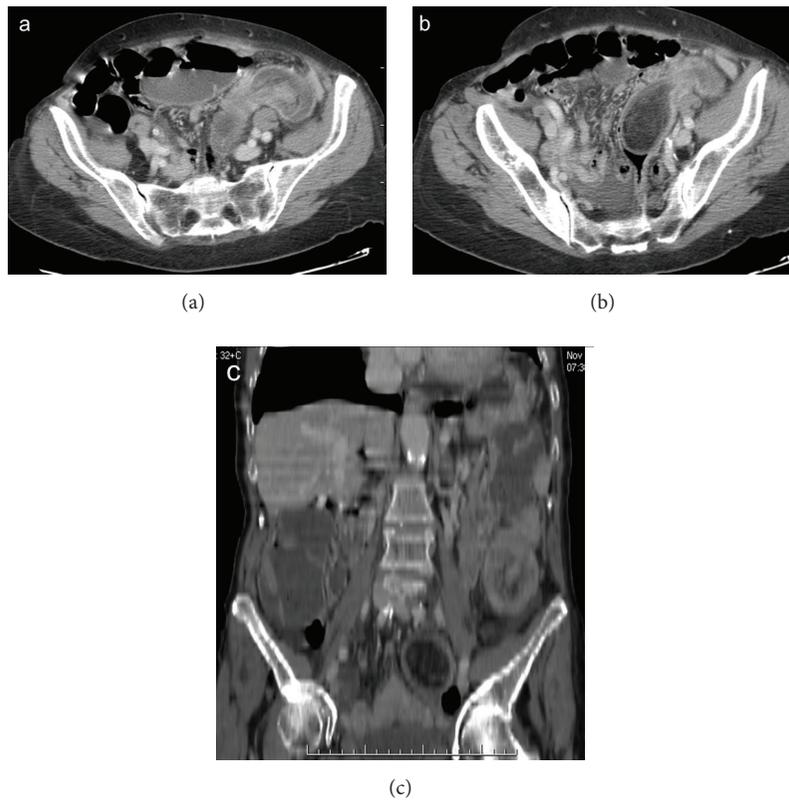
Colocolonic intussusception caused by a sigmoid lipoma. The intussusception is well depicted on axial CT scan (a). Both axial scan (b) and coronal reformatting (c) show the hypodense polypoid mass that acts as the lead point.
